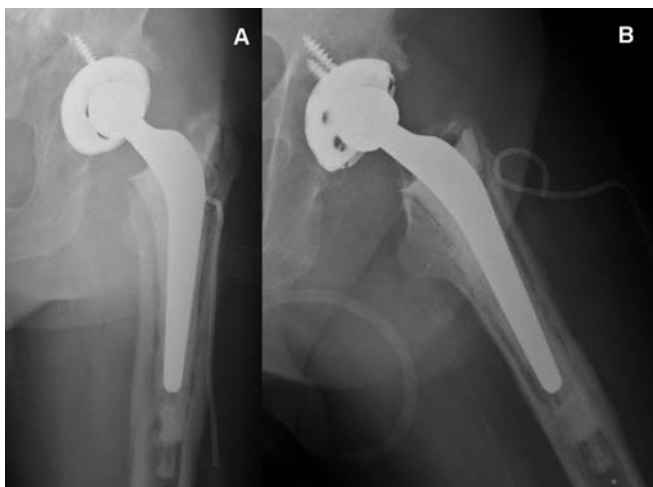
Posteroanterior (A) and axial (B) view x-ray imaging of pelvis showing left hybrid total hip arthroplasty (non-cemented cup, cemented stem).
